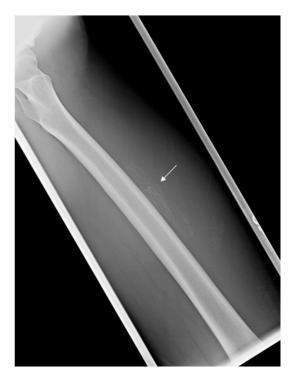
Conventional radiography of the femur approximately 6 weeks post injury demonstrating faint heterotopic ossification within the anterior thigh musculature (arrow).
